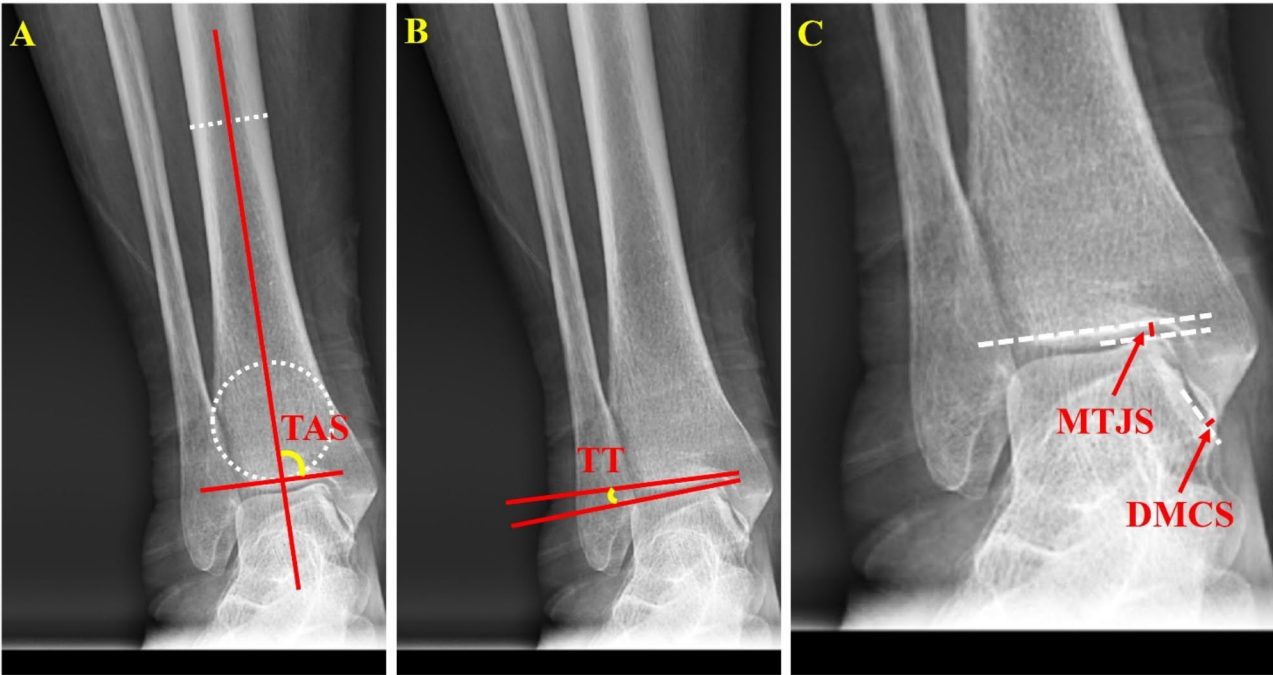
A, B, C were all partial enlarged images of total lower extremity weight-bearing AP radiograph, showing the measurement methods of several other ankle morphological parameters. (A) TAS was defined as the medial angle between distal tibial plafond and the anatomical axis of tibia. (B) TT was defined as the angle between distal tibial plafond and the upper joint surface of talus, and the angle opening to the lateral aspect of the ankle as shown in the figure was defined as a positive value. (C) MTJS was defined as the shortest distance between the medial end of talar dome and the distal tibial plafond, while DMCS was the vertical distance from the distal tip of medial malleolus to the medial articular surface of talus
